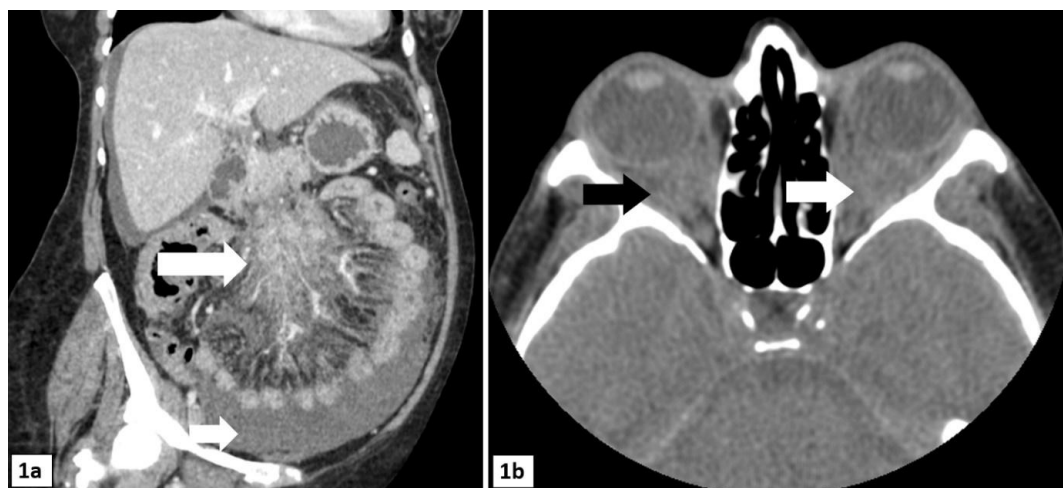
(1a), Abdominal CT. Mesenteric and retroperitoneal infiltrative mass surrounding mesenteric vessels and the inferior vena cava (big arrow). Free intraperitoneal fluid (small arrow). (1b), Cranial TC. orbital inflammatory pseudotumor (arrows).
